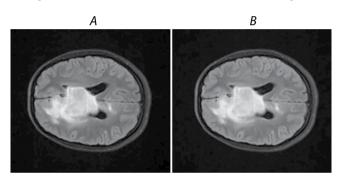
Diffuse glioma (T2-FLAIR, ax). A – raw data; B – AdjustContrast transformed (γ = 0.9).
